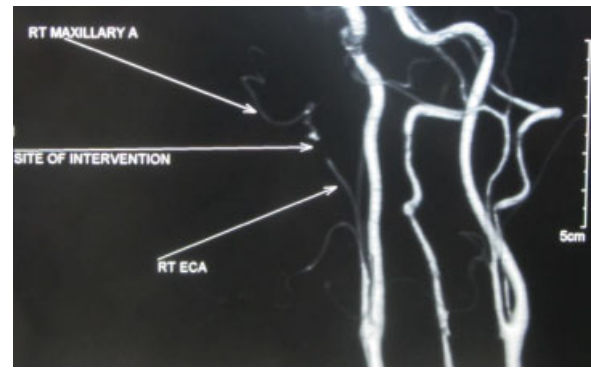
Follow-up computed tomography angiogram at 11 months.
